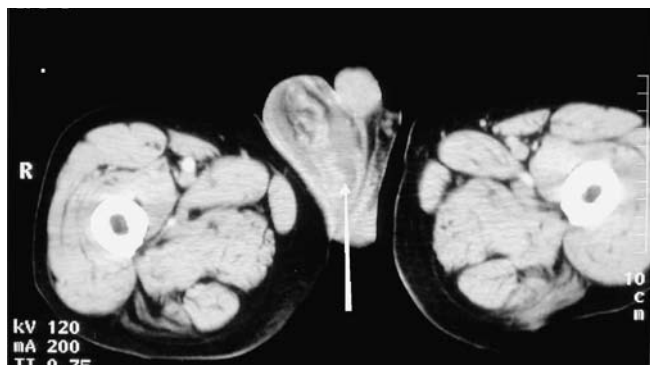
Biliscrotum. Axial CT scan at the level of the scrotum/inguinal canal showing bile extending around the pampiniform plexus.
